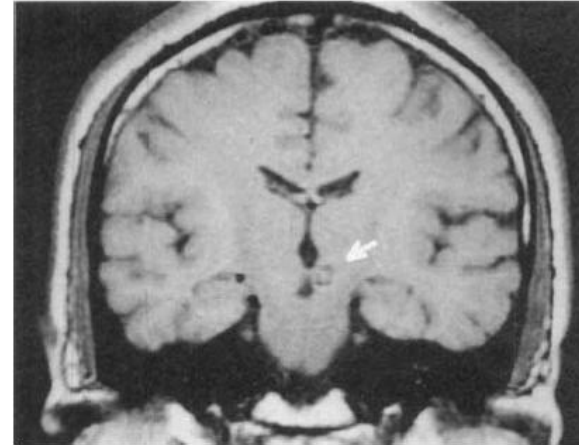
Magnetic resonance imaging (MRI) of a coronal T1-weighted scan of patient 1 showing a left paramedianthalamomesencephalic infarct (A); an axial T1-weighted scan of patient 4 showing a left medial mesencephalic infarct (B); an axial T1-weighted scan of patient 5 showing a large left mesencephalic infarct associated with a left temporo-occipital infarct (C); an axial T1-weighted scan of patient 7 showing infarct in the right superior cerebellum, the right superior cerebellar peduncle, and the upper part of the pons (D); and E, an axial T2-weighted scan of patient 3 (4 days after a stroke), showing a right paramedianmesencephalic infarct involving the dopaminergic area. F, A control scan of patient 3, taken 1.5 years after (E), is axial, T1-weighted, and shows a small residual tegmental lesion close to the aqueduct of Sylvius, sparing the nigrostriatal dopaminergic system. At the time of the study, dystonia was no longer present. Note a decreased width of the right cerebral peduncle. The white line represents the anterior-posterior commissure.
